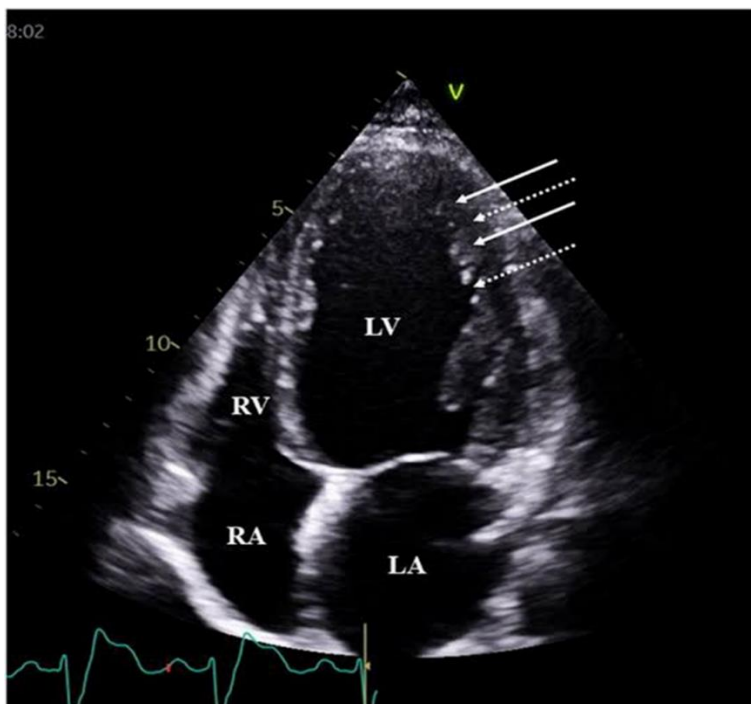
Transthoracic echocardiogram (apical four-chamber view) showing prominent trabeculations (arrows) and deep intertrabecular recesses in the RV apex.
